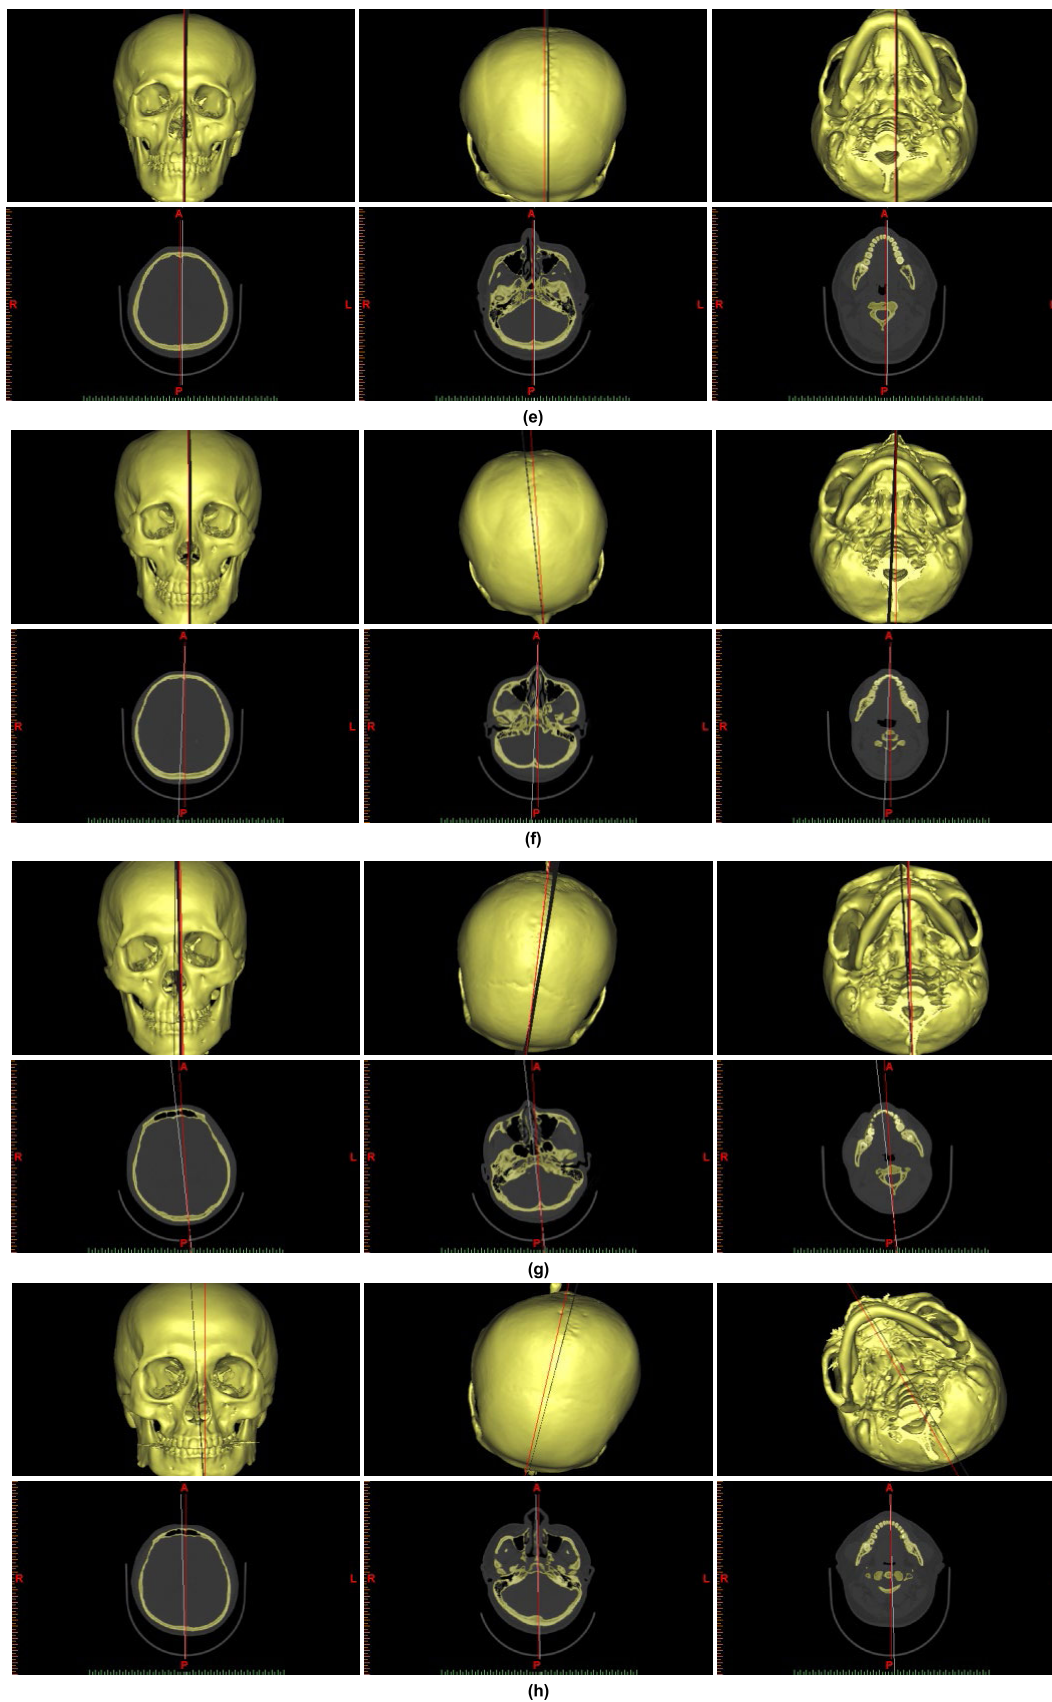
(Continued.) The comparison results of the 10 patients' head CT image datasets of doctor's manual method and this method: (a-i) figures are the result of the 10 patients' head CT image datasets.
